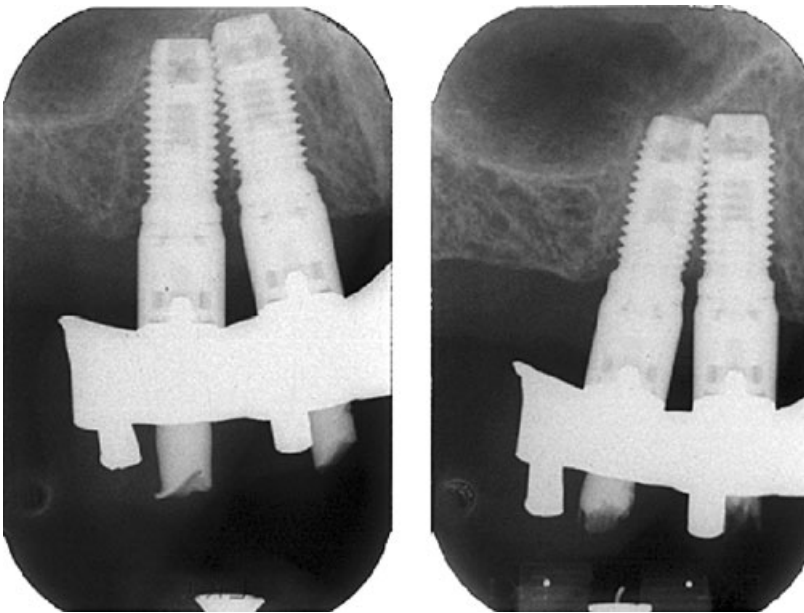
Two implants placed very close to each other. A control radiograph taken 1 year after bridge connection (on right) demonstrates, by the thin radiolucent lines around the implants, that they have not become integrated with the surrounding bone.
